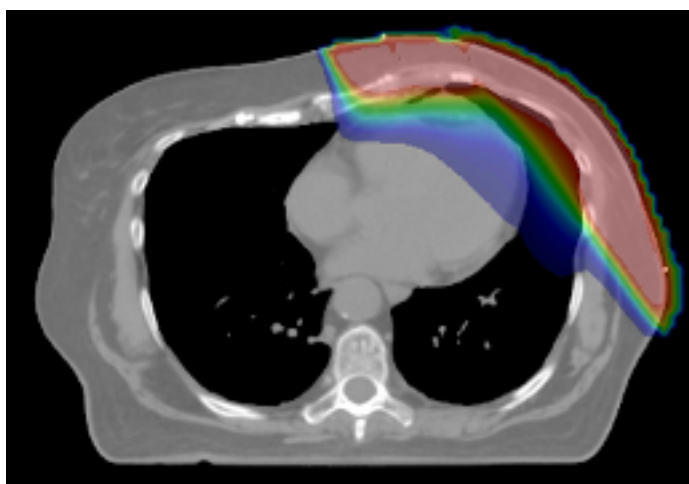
CT Scan of Chest acquired from our patient dataset
